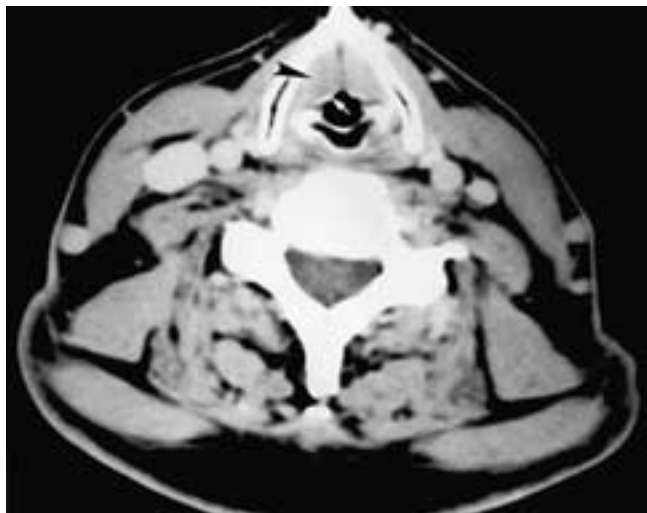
Axial CT with breath-holding. The true cords are apposed. *Arrowhead*, TAM; *arrow*, vocal process.
